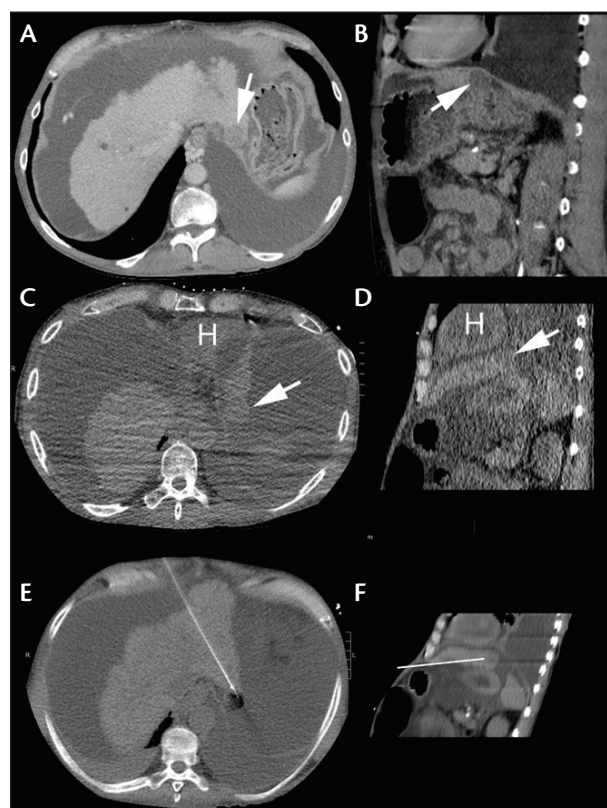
Axial (A) and sagittal reformat (B) contrast-enhanced CT obtained in inspiration. Axial (C) and sagittal reformat (D) noncontrast-enhanced CT obtained during apnea when patient was placed under general anesthesia. Axial (E) and sagittal reformat (F) CT obtained after angling the gantry 22.5° caudally.
